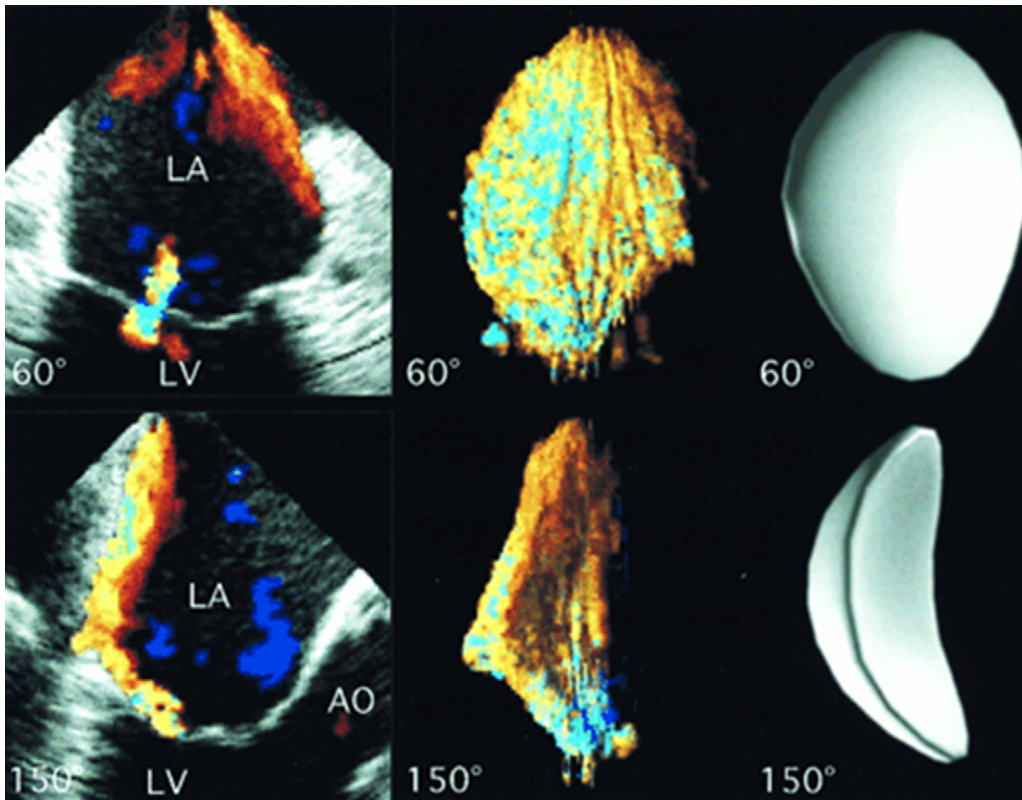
Mitral regurgitation jet with a spoon pattern in a patient with anterior prolapse. Visualization of the jet in two dimensions at 600 and 1500 only demonstrates portion of the jet (left, top, and bottom panels). 3D reconstructions, using the Heidelberg Ray tracing method enables display of 3D color flow (middle panels) and surface-rendered images (right, top, and bottom panels). (From De Simone R, Glombitza G, Vahl CF, et al. 3D color Doppler: a clinical study in patients with mitral regurgitation. *J Am Coll Cardiol* 1999;33:1646–54; with permission.)
